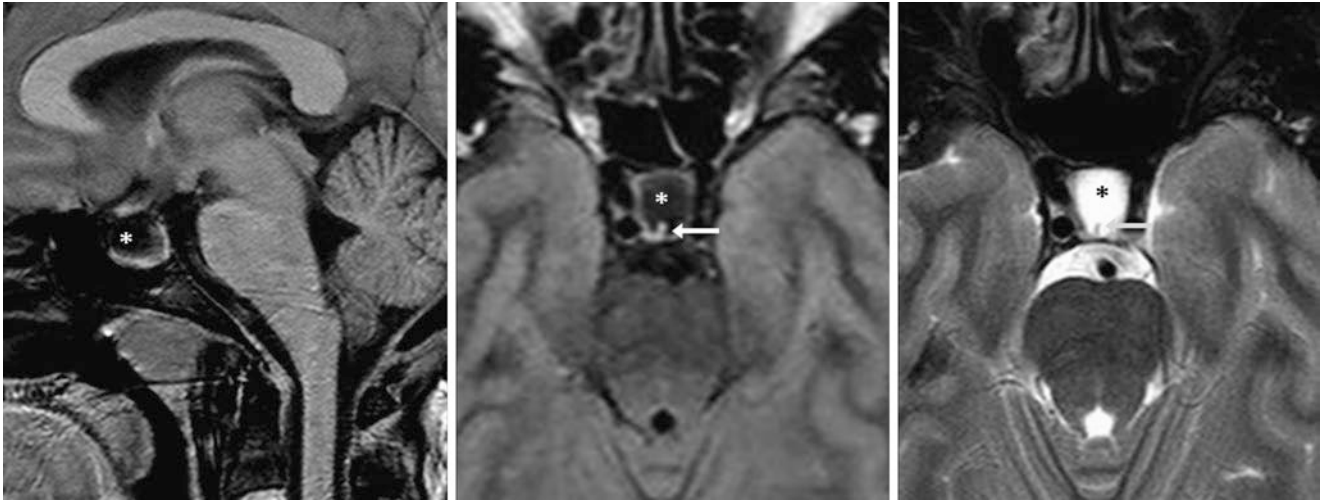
A 35-year-old female patient had an incidental PES (*) on a 1.5 T MRI. The bony contour of the sella is slightly enlarged. The stalk (arrows) was not visible on noncontrast sagittal T1WI (left) but is
